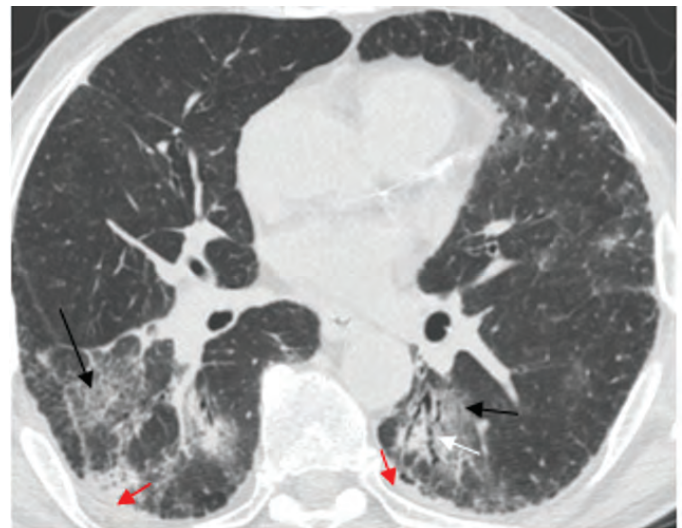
Axial CT image showing irregular consolidative infiltration in association with patch bilateral GGOs (black arrows) in a 71-year-old immunocompromised male patient presenting with dyspnea and fatigue who had a history of lung cancer, hypertension, type 2 diabetes mellitus and who was discharged from the hospital 14 days after being hospitalized for COVID-19 pneumonia. Note also bilateral small amounts of pleural effusion (red arrows) and the irregularly dilated bronchioles (bronchiectasis) (white arrow) in association with the pneumonic infiltration in the left lower lobe
